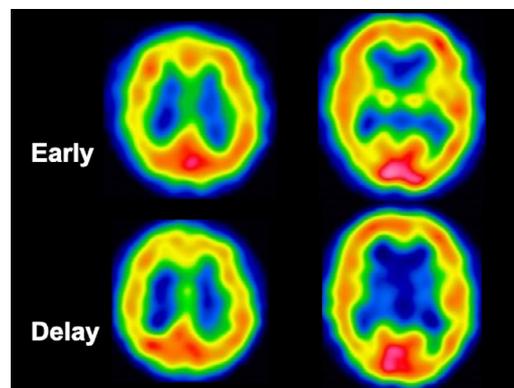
$^{123}\text{I}$ -iodoamphetamine single photon emission computed tomography images 2 days after seizure onset. Early images (upper row) reveal an increase in tracer uptake in the right cerebral hemisphere compared with the contralateral hemisphere. Delayed images (lower row) reveal a decrease in tracer uptake in the right cerebral hemisphere compared with the contralateral hemisphere, corresponding to the region of sulcal hyperintensity on fluid-attenuated inversion recovery images.
